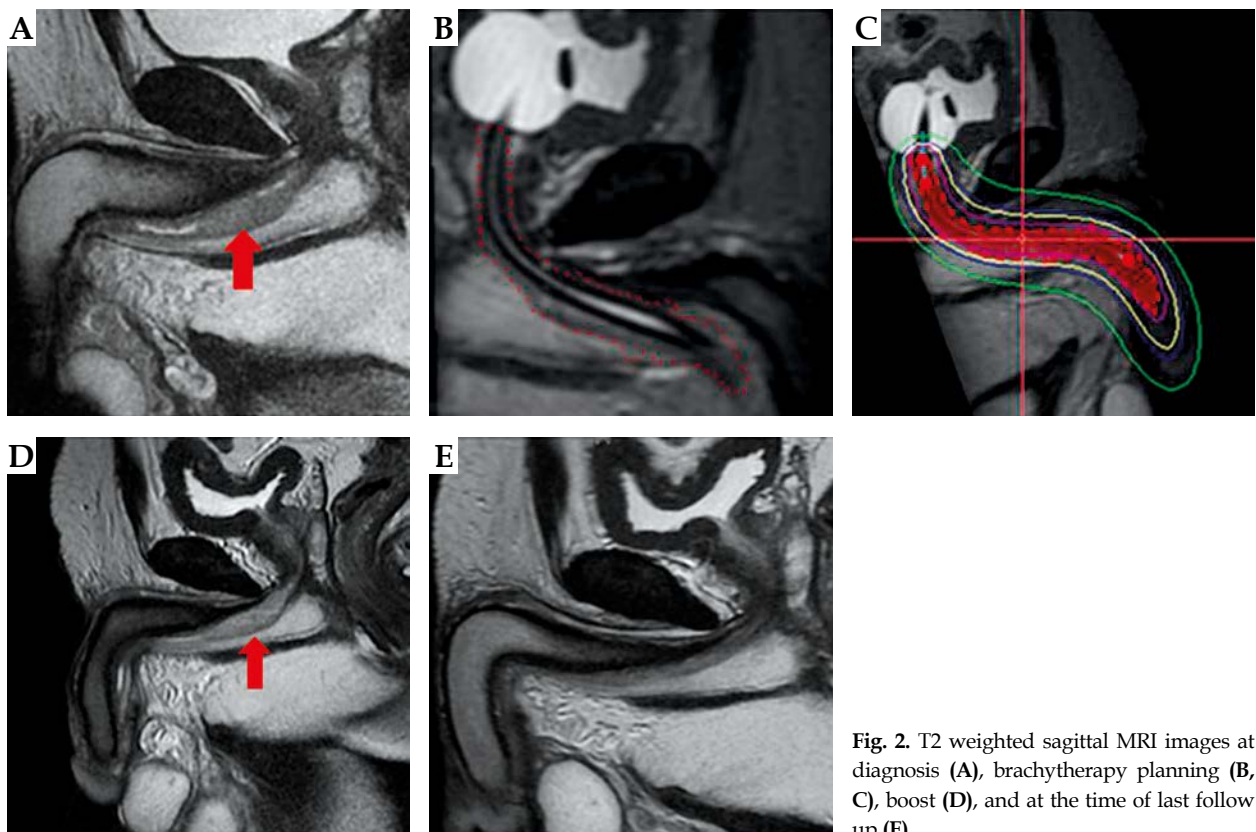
T2 weighted sagittal MRI images at diagnosis (A), brachytherapy planning (B, C), boost (D), and at the time of last follow up (E)
